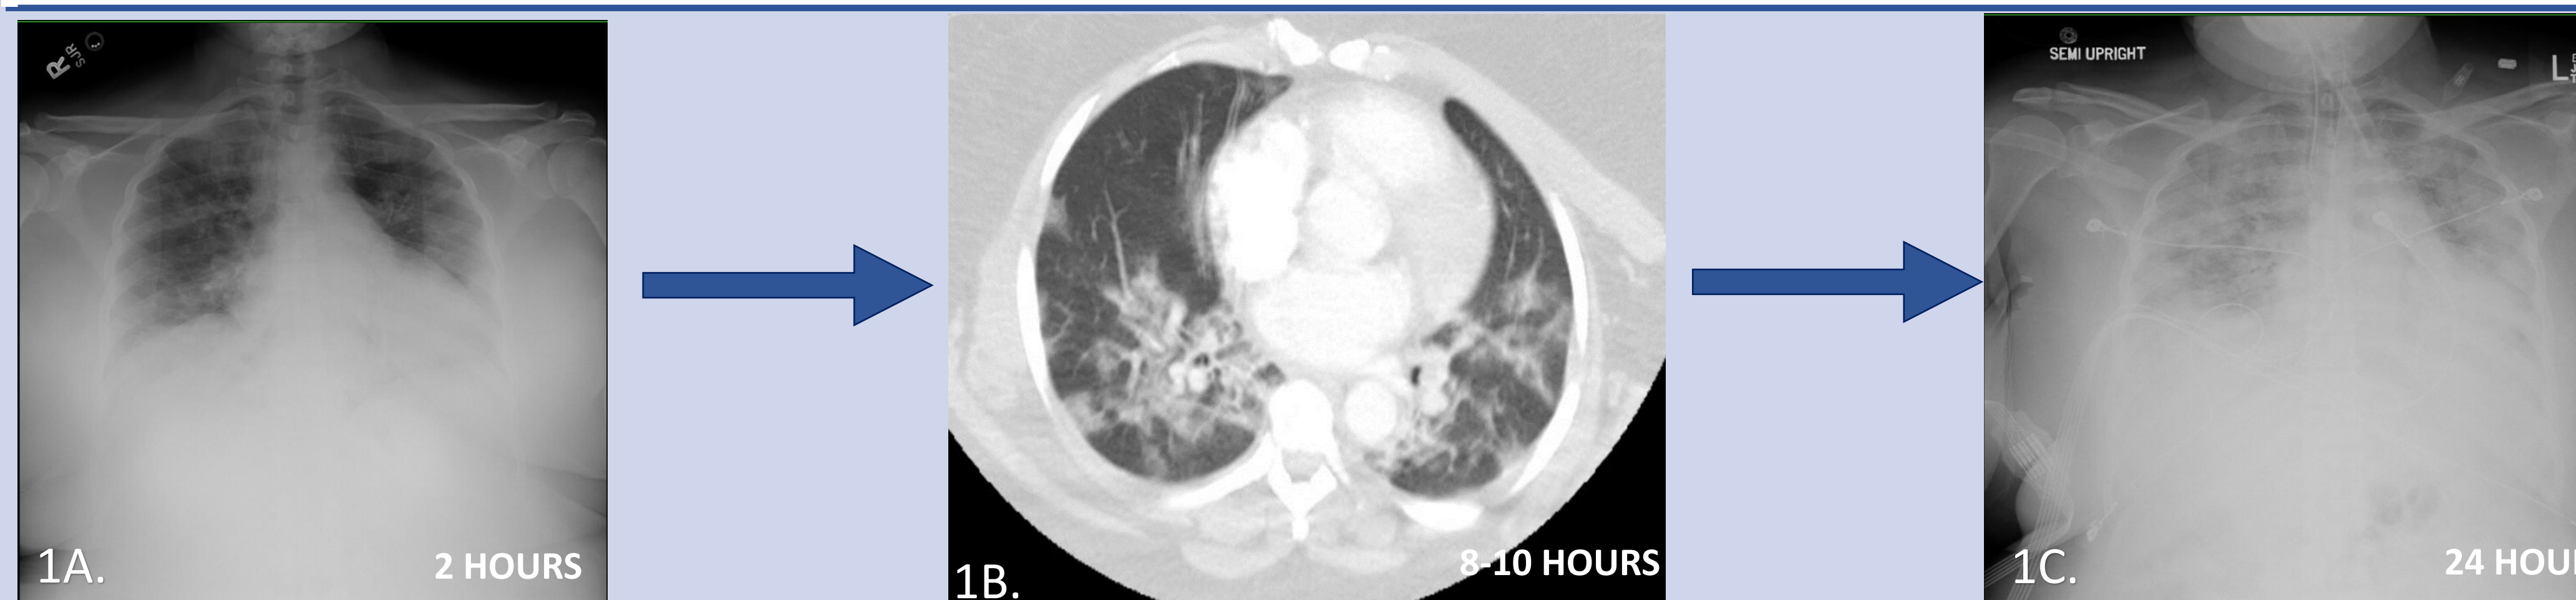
Description: Images shown in chronological order of worsening pulmonary status post hospital admission. (1A) Chest X-ray performed 2 hours after hospital admission showing moderate bilateral lower lobe pulmonary infiltrates. (1B) CT Pulmonary angiogram with concern for possible pulmonary embolism showing ground-glass opacities in bilateral middle and lower lobes. Performed 8 hours after admission. (1C) Chest X-ray performed approximately 24 hours after admission due to worsening respiratory status.
